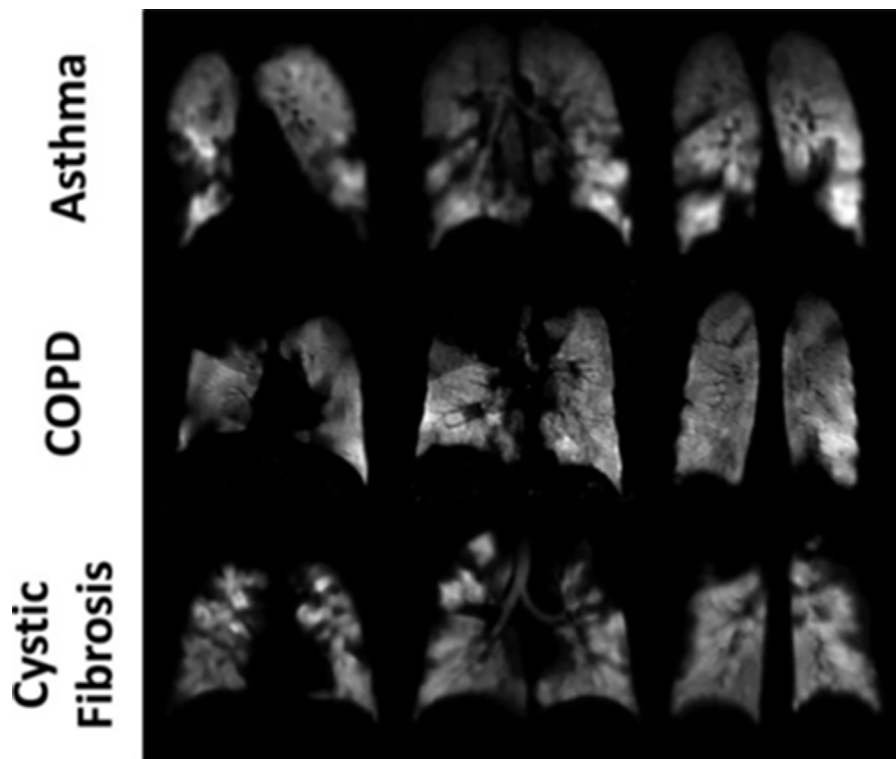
Ventilation imaging of the diseased human lung using ^{129}Xe -MRI. Coronal ventilation images were acquired in subjects with asthma (upper row), COPD (middle row), or cystic fibrosis (lower row). Numerous ventilation defects can be seen in each of the images secondary to airflow obstruction caused by the underlying diseases. Figure taken from Mugler, J. P. et al., *Journal of Magnetic Resonance Imaging* (85).
